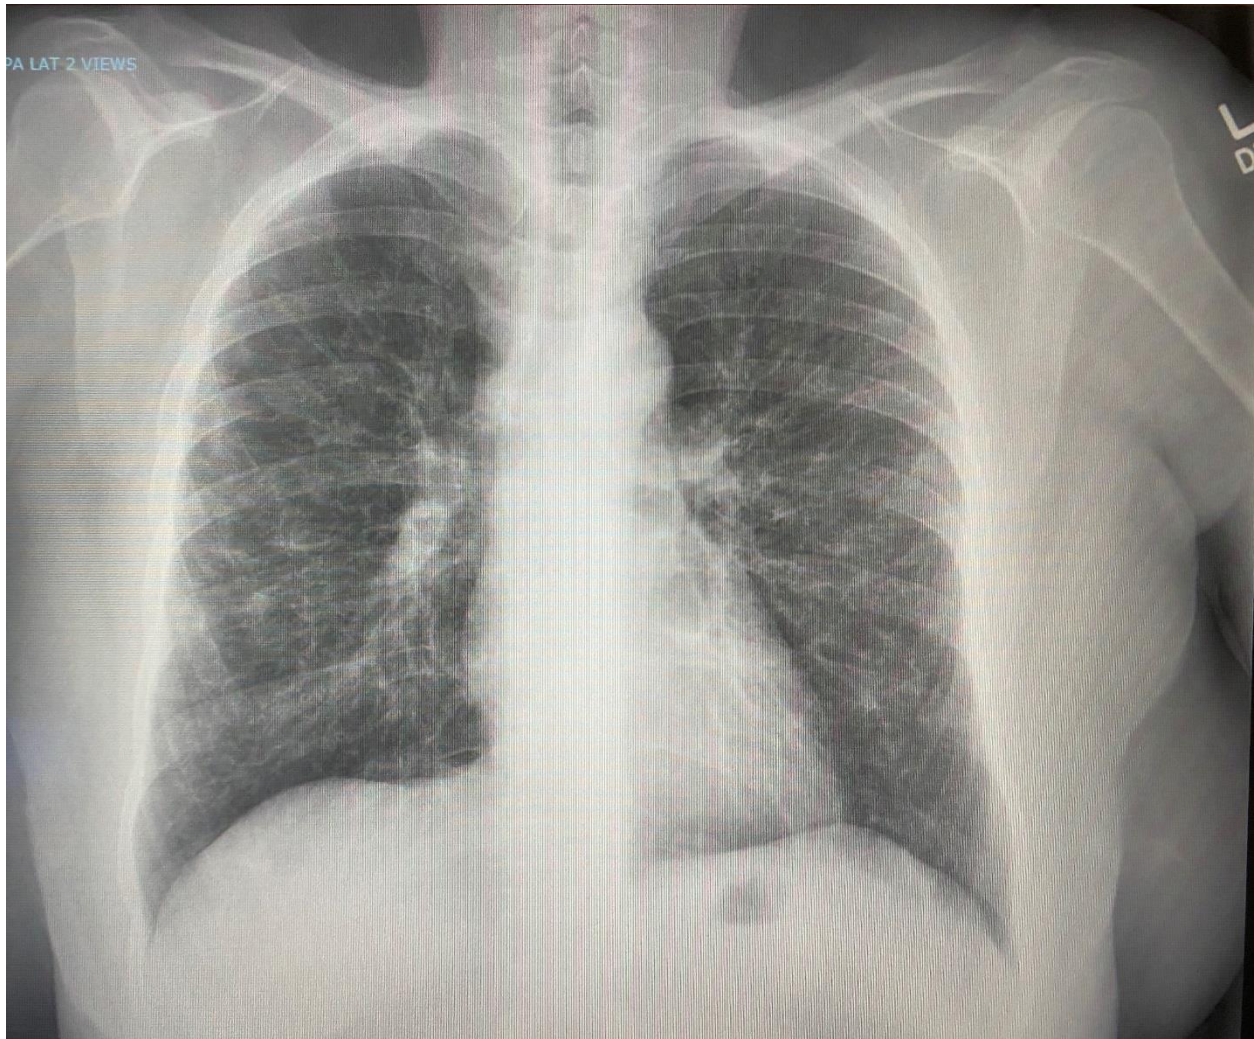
Day #23, chest x-ray improved with remaining predominantly peripheral bilateral infiltrates
